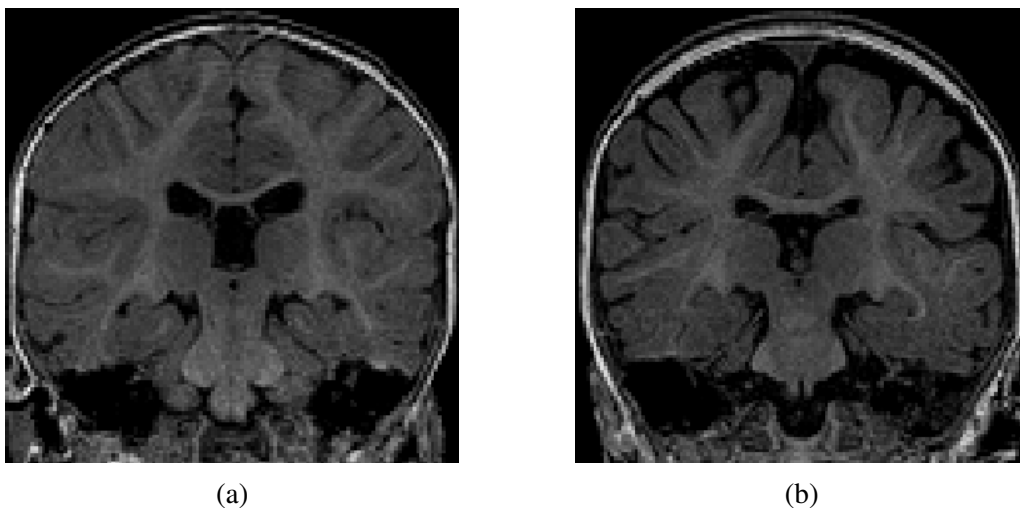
(a) T1w image of an infant with a normal MRI at 6 months of age. (b) Similar T1w image of an infant with enlarged EA-CSF at 6 months, who was diagnosed with ASD at 2 years of age. The dark regions between the brain folds and skull indicate increased amounts of EA-CSF.
